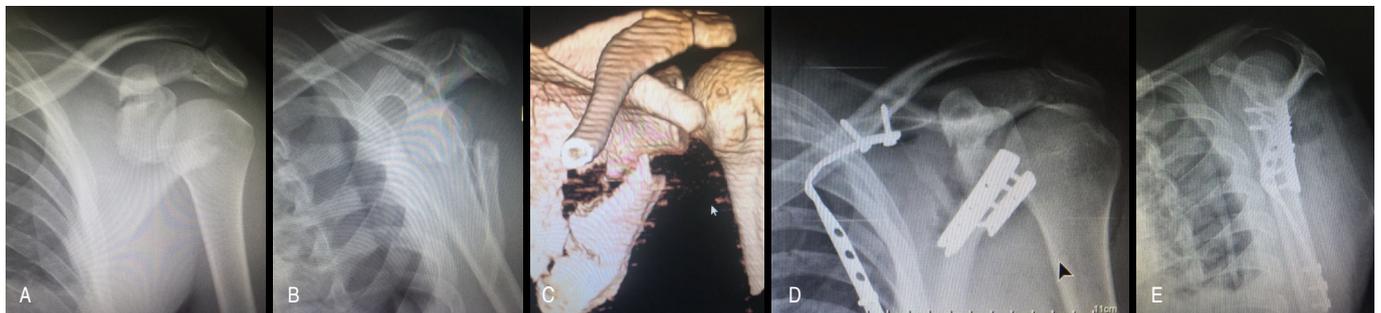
A: Anteroposterior radiograph of the shoulder of a 28-year-old patient with AO type 14F1.2 fracture; B: Perfil radiograph shoulder showing a translation greater than 100%; C: Computed tomography scan with 3D reconstruction; D and E: Postoperative AP and profile radiographs highlighting the fixation of small fragments with plates on the lateral and medial borders of the scapula.
